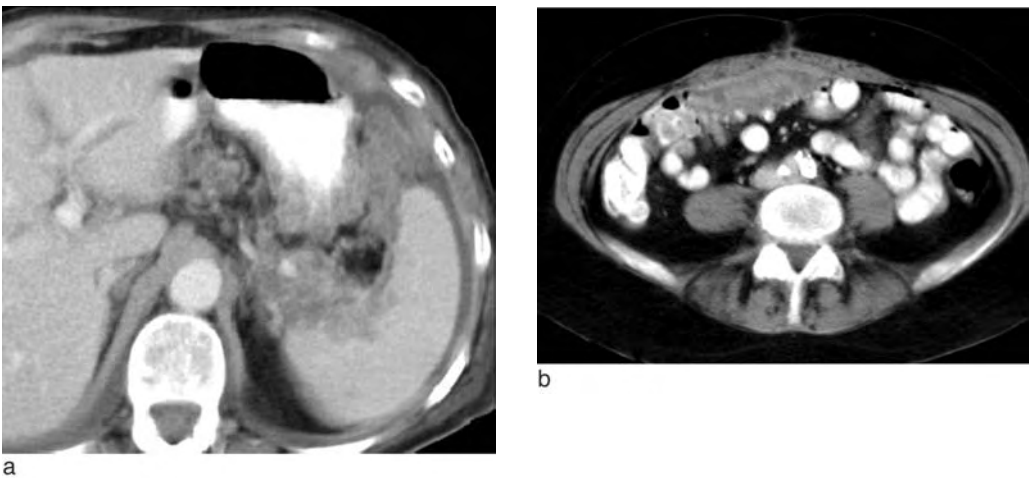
Contrast-enhanced CT of stage IIIC ovarian cancer. (a) Extensive left upper quadrant tumour invading the spleen and stomach and (b) omental tumour directly invading the anterior abdominal wall.
